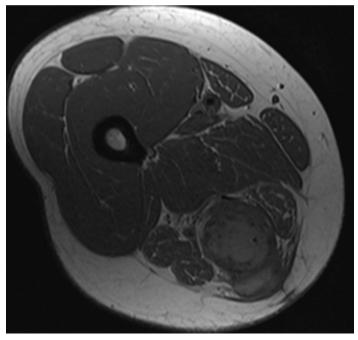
T1 Axial MRI at greatest cross-sectional area of tumor prior to initial biopsy and procedure demonstrates a heterogeneous mass in the posterior compartment of the thigh $(4.5 \times 4.0 \times 10.1 \text{ cm})$.
